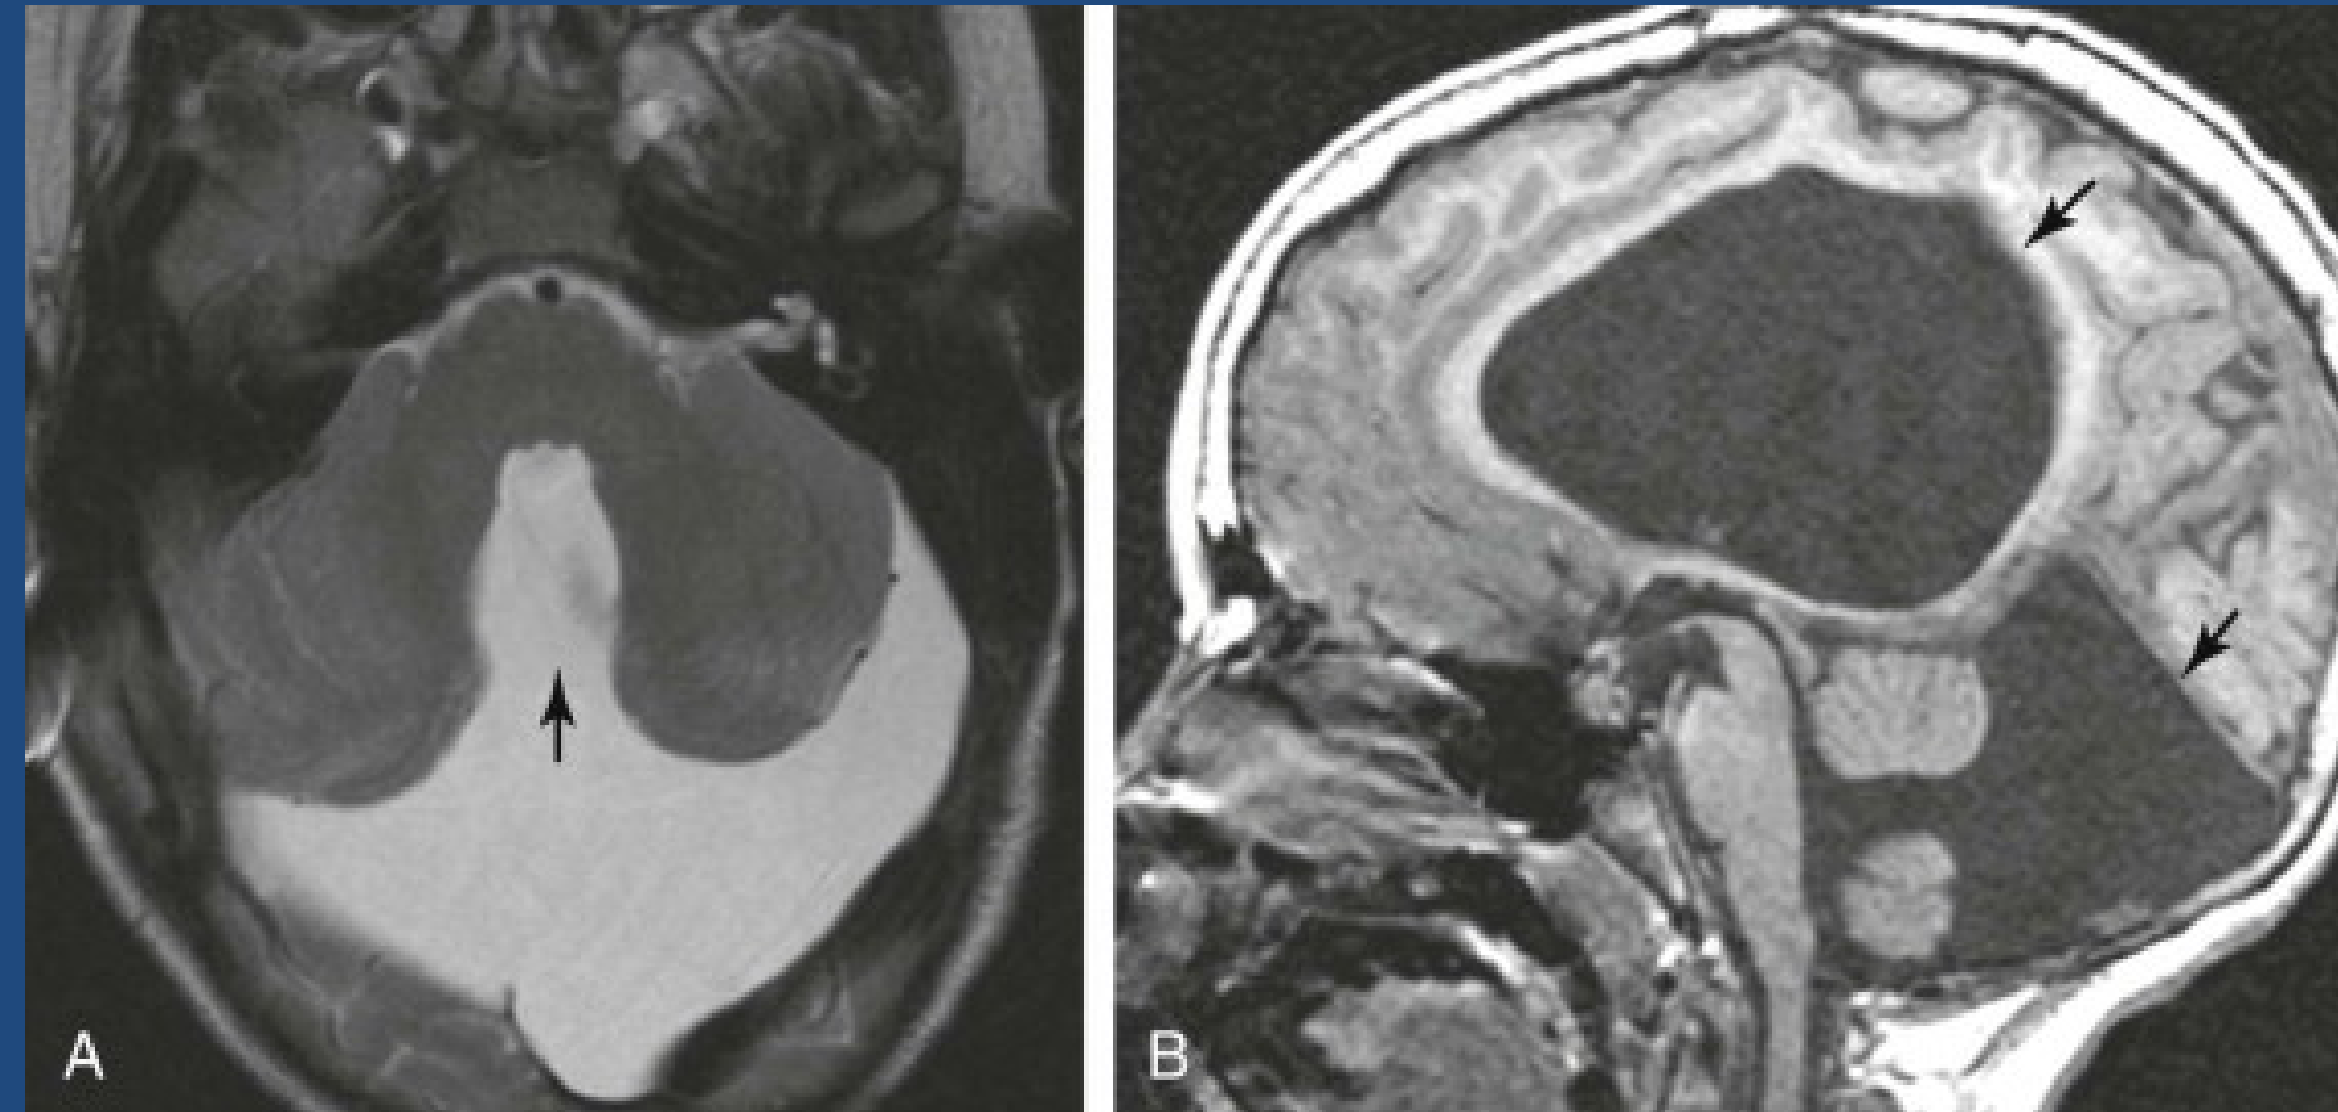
Dandy-Walker Malformation with Enlargement of Posterior Fossa. A) T2 Weighted MRI. Absence of cerebellar vermis (arrow). B) T1 weighted MRI. Elevation tentorium (bottom arrow) and Hydrocephalus.⁷ Image obtained from Clinical Key
